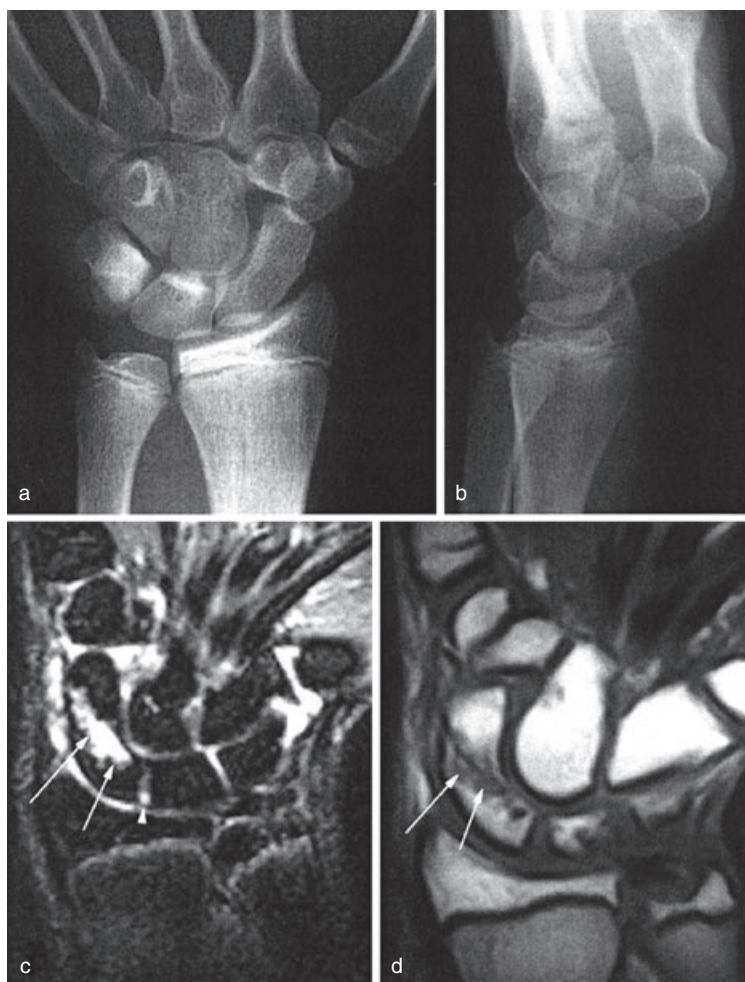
Magnetic resonance imaging (MRI) scan. On plain radiographs a scaphoid fracture is not identified. A non-contrast fat saturated coronal T2-weighted image demonstrates signal alteration of the scaphoid bone (lower left image with arrows) due to the occult scaphoid fracture. The T1-weighted image (lower right) verifies the scaphoid fracture (arrows). The scapholunate ligament is intact (arrow head). (With kind permission of Springer Science and Business Media – Mack MG, Keim S *et al.* *Clinical impact of MRI in acute wrist fractures.* *Eur. Radiol.* 2003; 13: 612–7, fig. 1.)
